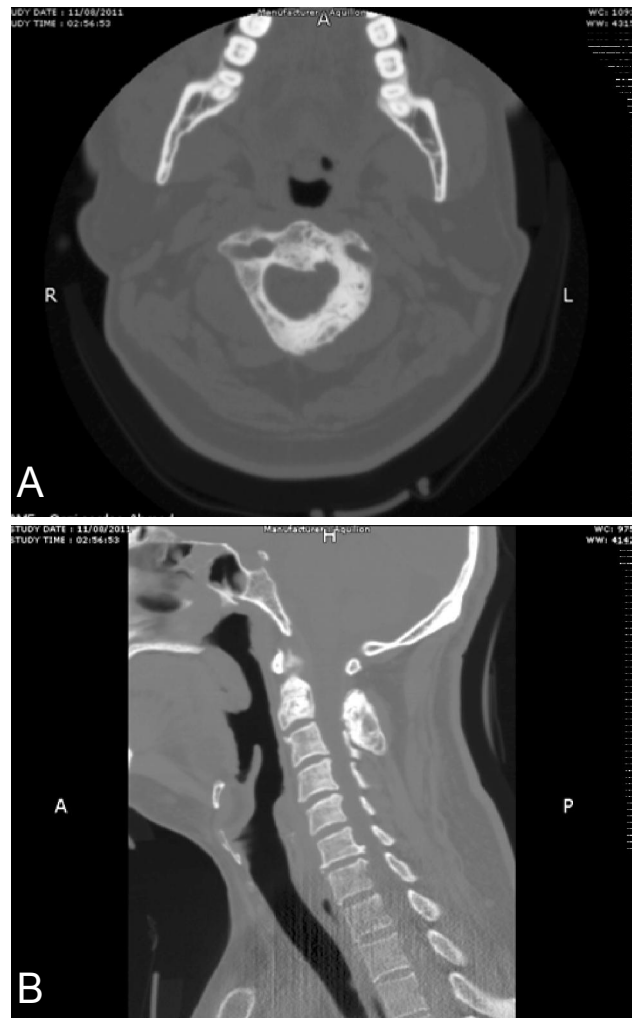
CT scan (A: axial, B: sagittal, C: 3 D, of a different patient) showing sclerosis and coarsening of the trabecular pattern along with expansion is identified involving the body, lamina, left pedicle as well as spinous process of the C2 vertebra (predominantly the left side).
